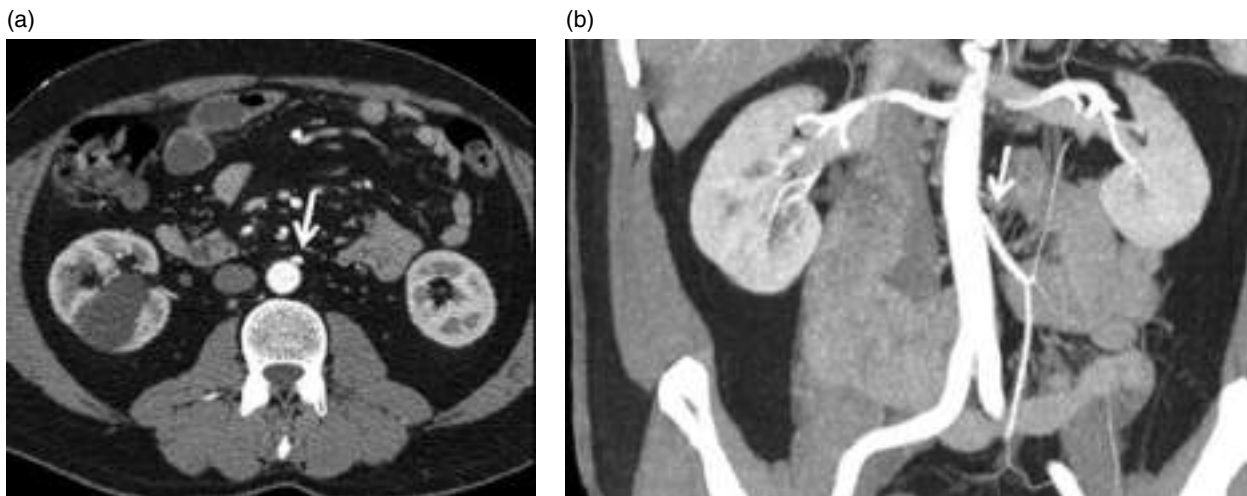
Inferior mesenteric artery. (a) Axial contrast-enhanced CT image (arterial phase). (b) Coronal contrast-enhanced MIP CT image (arterial phase).
